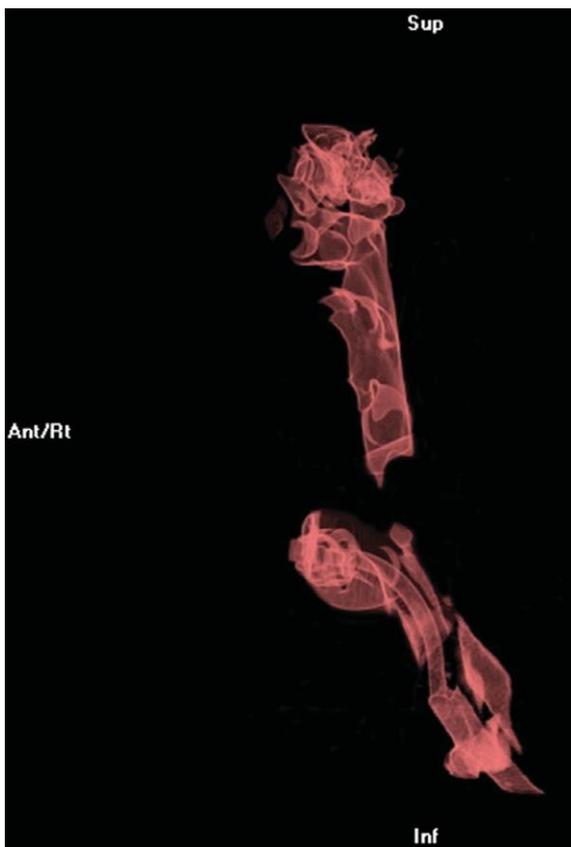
Computed tomography three-dimensional reconstruction of recipient's airway demonstrating complete glottic, subglottic, and proximal tracheal stenosis. Ant = anterior; Inf = inferior; Rt = right; Sup = superior.
